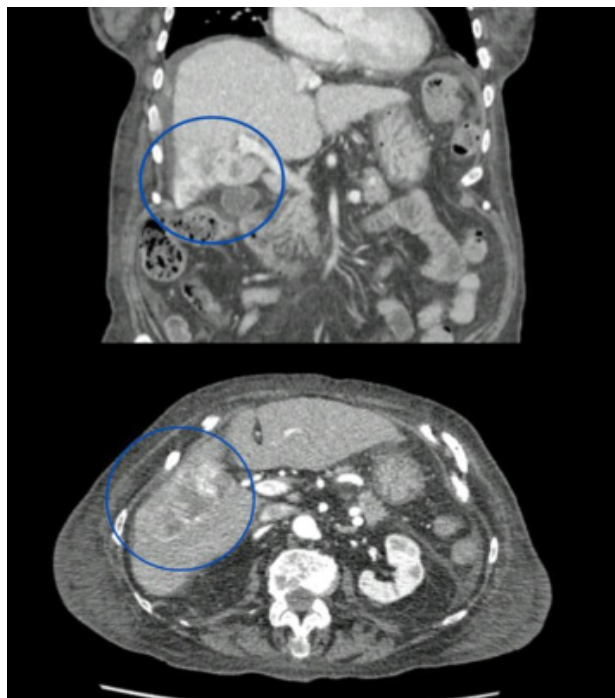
(A and B) – Abdominal CT scan showing hepatic mass – coronal and transverse plane respectively.
